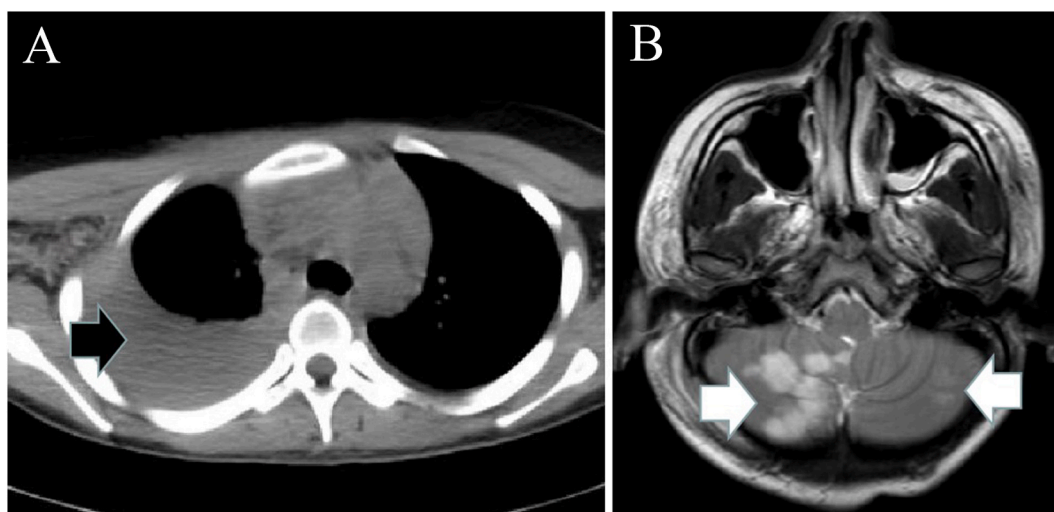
Images of hemothorax and cerebellar infarction. A. Chest CT showed massive right hemothorax (black arrow). B. Head MRI revealed bilateral cerebellar infarction (white arrow), and the right lesions were more severe than those of the left.
